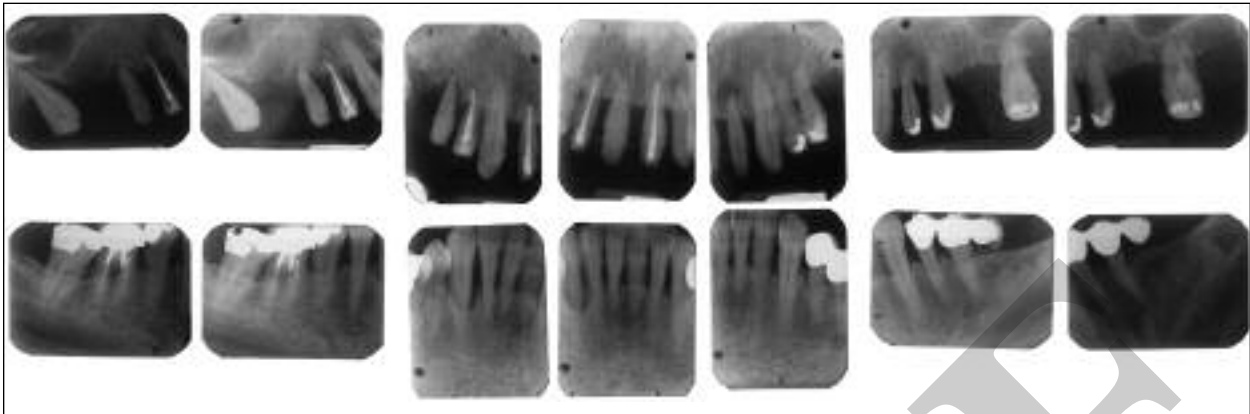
Preoperative full-mouth periapical radiographs revealed severe periodontal damage of the natural dentition.
